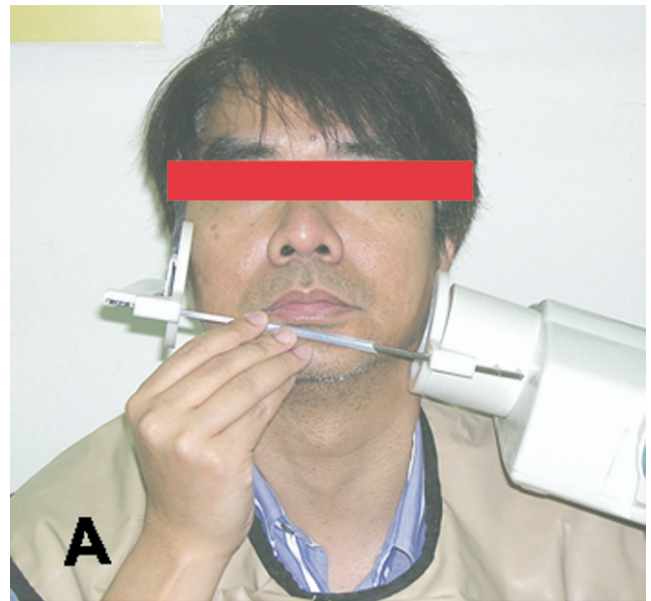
(A) Taking an image of the right lower third molar area using the extraoral radiographic technique under the guidance of the aiming device; (B) the resultant image shows the right lower second molar. No third molar is noted, but the alveolar canal can be seen (arrow).
